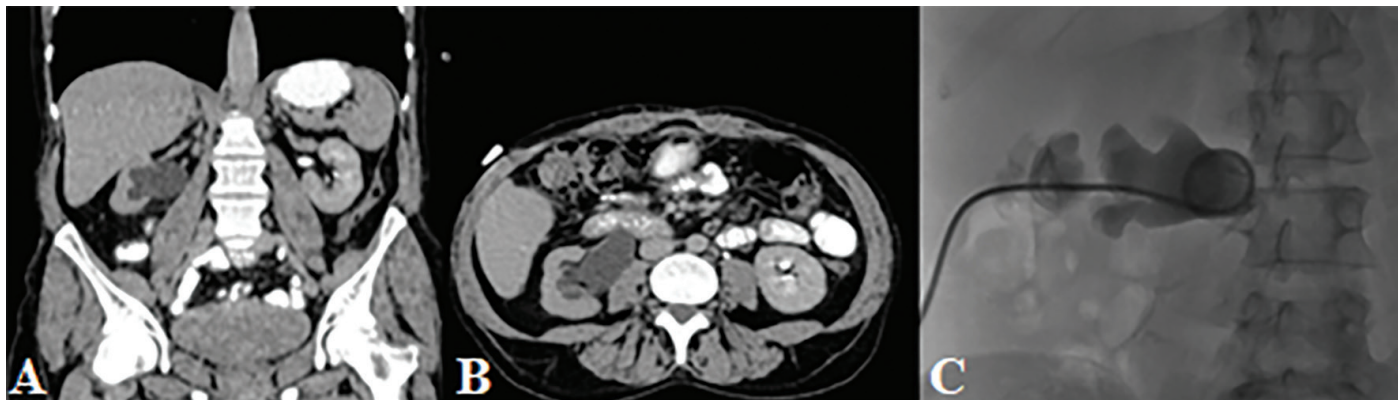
Computed tomography (CT)-urography and antegrade pyelography images of Case 2 in the preoperative period. A. Coronal CT image B. Axial CT image C. After the placement of a right nephrostomy tube, antegrade pyelography image reveals complete proximal ureteric obstruction
